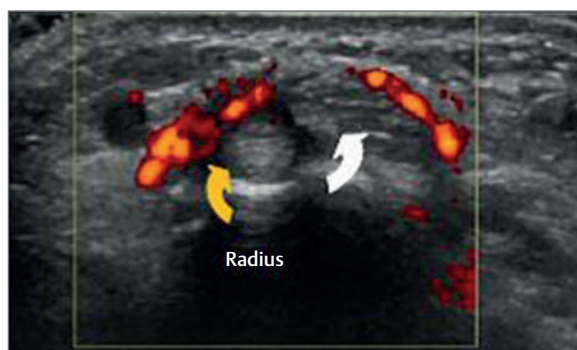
Transverse image of the first dorsal compartment of the wrist and the tendons of abductor pollicis longus (curved yellow arrow) and extensor pollicis brevis (curved white arrow). Although there appears to be no effusion or synovial thickening within the sheath, Power Doppler imaging demonstrates a marked synovitis in keeping with a de Quervain's tenosynovitis.
